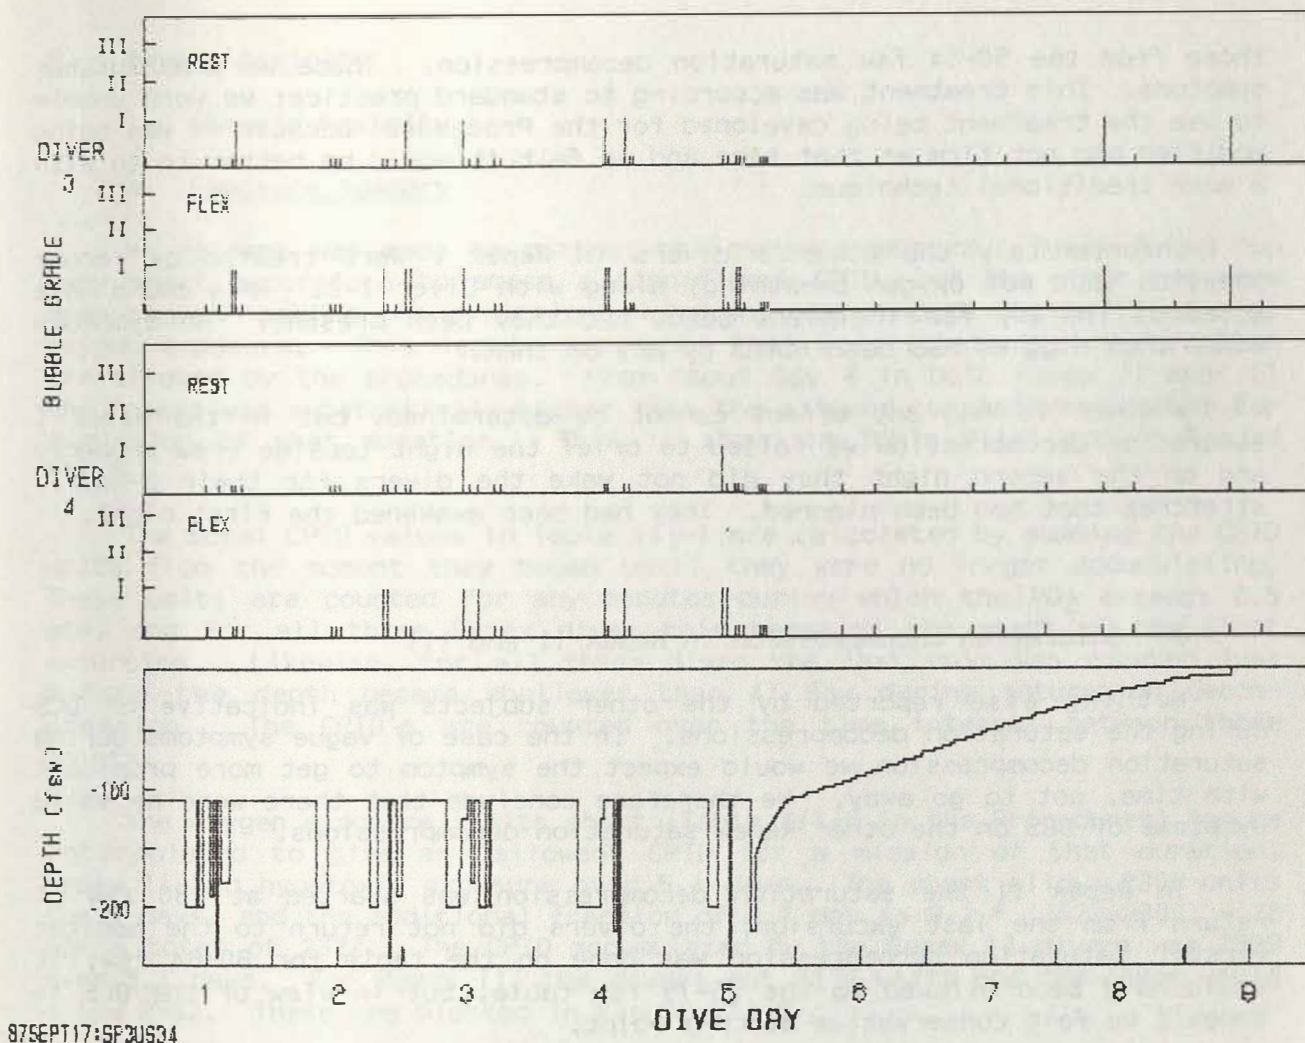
Repex III doppler scores, Divers III-3 and III-4
